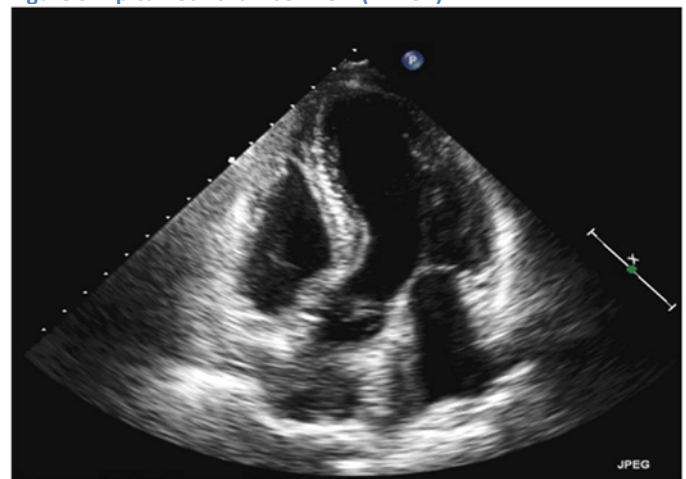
Apical five chamber view (AP5CH)
